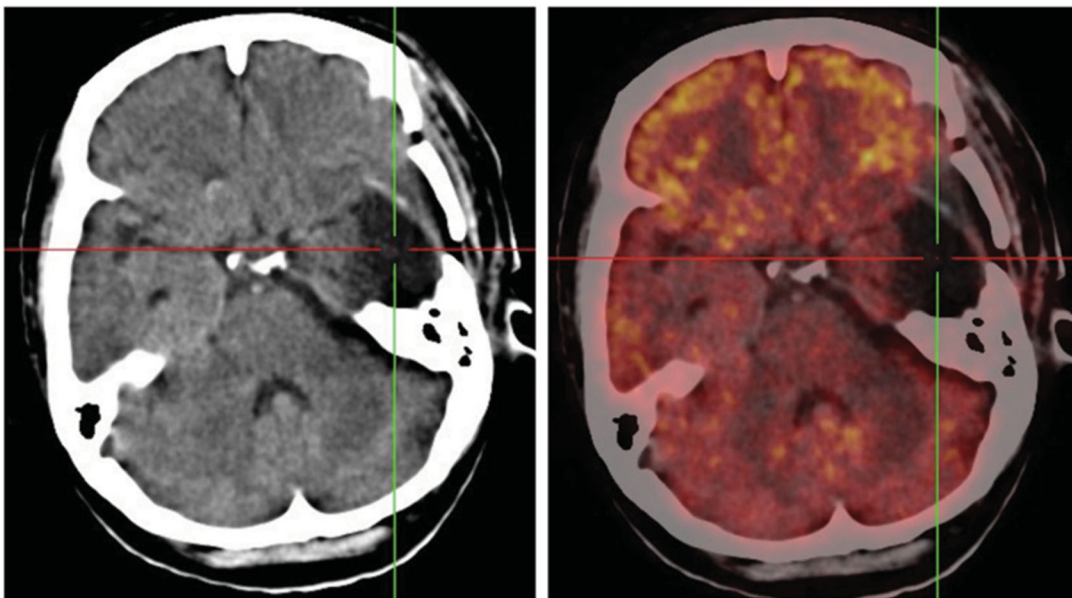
A full-body PET scan only revealed the smaller remaining tumor on the contralateral side had increased uptake – the highest standardized uptake values (SUV) of 2.6, which indicates a malignant lesion.
